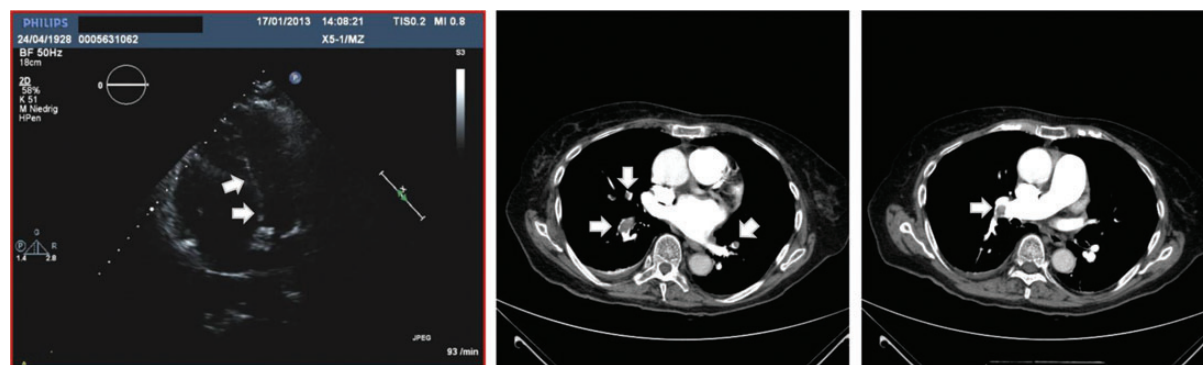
A patient with recurrent syncope and an initial diagnosis of acute coronary syndrome. Left panel: bedside transthoracic echocardiography (apical four-chamber view) showed an enlarged right ventricle with end-diastolic bowing of the interventricular septum towards the left ventricle (arrows). Middle and right panels: Computed tomographic angiography of the chest revealed multiple filling defects in the branches of both pulmonary arteries (arrows).
